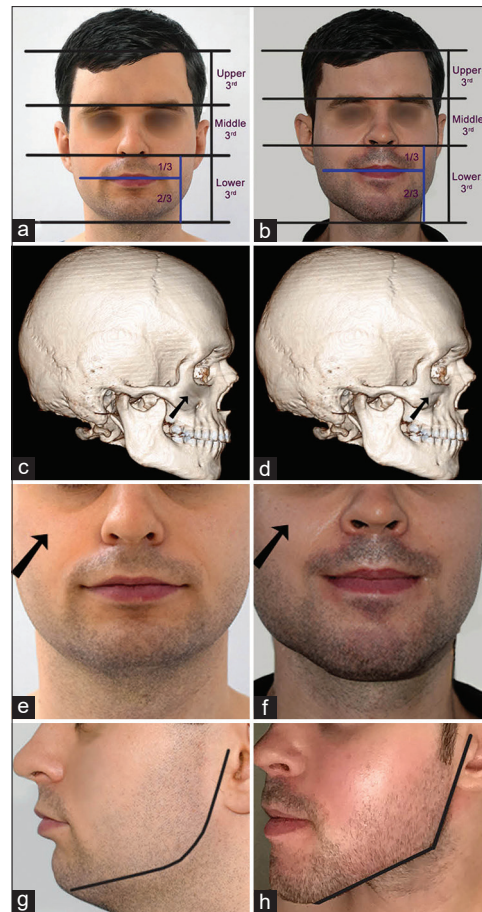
(a and b) Pre- and post-operative view showing facial proportion changes. (c-f) Three-dimensional computed tomography scan and frontal view showing before and after zygoma augmentation. (g and h) Pre- and post-operative view showing increase in mandibular angle
